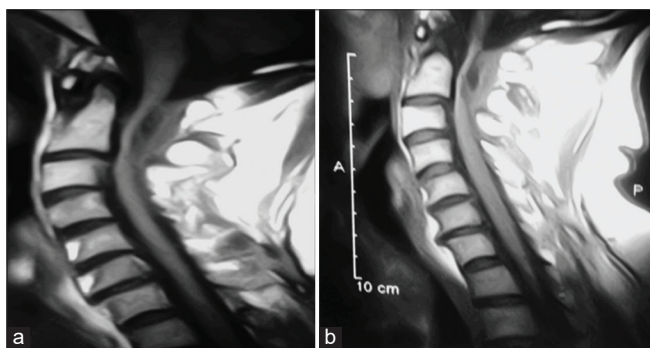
(a and b) T1WI midline and paramedian sagittal magnetic resonance imaging of cervical spine showing a hypointense area of calcification/ossification 7.02 cm × 2.58 cm (CC × AP) opposite the C1/C2 level resulting in severe thecal sac and spinal cord compression.
